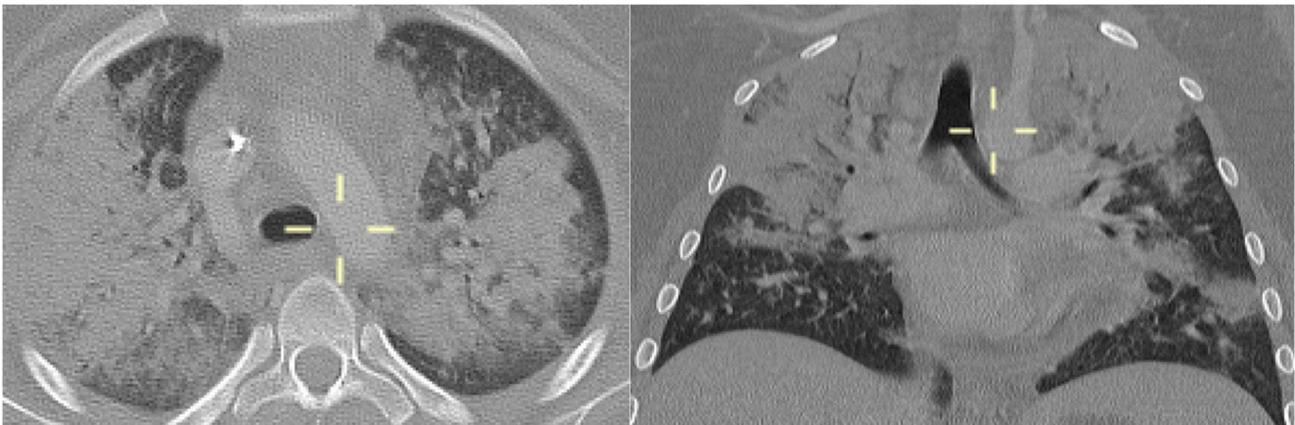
Axial and coronal MPR CT reconstitution (patient 3)—bilateral areas of pulmonary consolidation with air bronchogram with a typical distribution preferentially involving the upper lobes and diffuse interstitial thickening.
